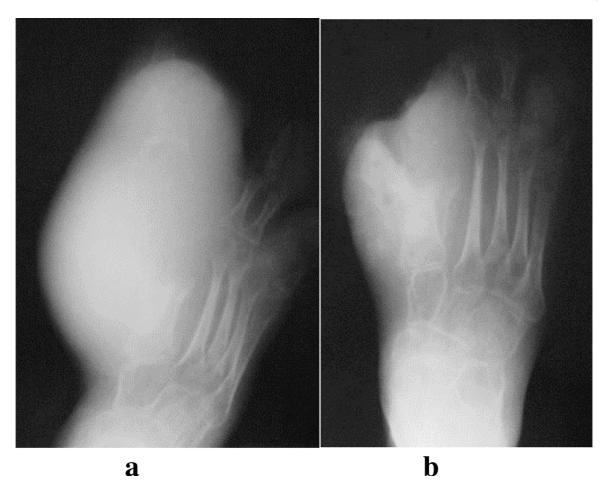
Hemophilic pseudotumor. Previous radiography (a) shows a hyperdense mass on the medial aspect of the forefoot and midfoot in a known hemophiliac. After a few weeks (b), with resorption of some of the hyperdense content, bone erosions are more apparent in the hallux.
